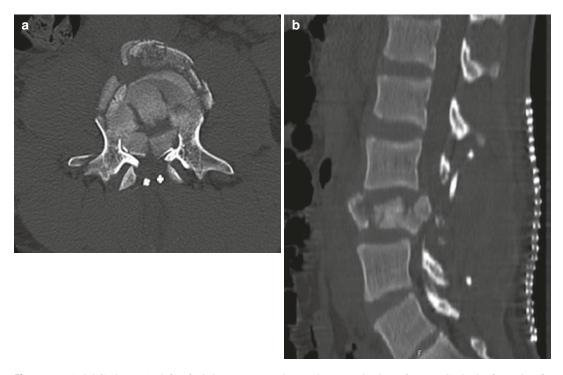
Axial CT image (\mathbf{a} , left) of L3 demonstrates a three-column combat burst fracture. Sagittal reformation (\mathbf{b} , right) demonstrating the same L3 three-column combat burst fracture
